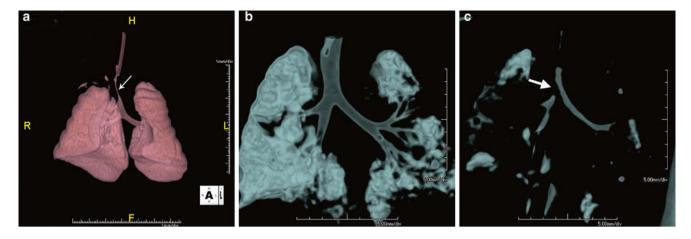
(a) shows CT 3D colorful reconstruction of an infant with longsegment tracheal stenosis previously unrecognized on conventional radiologic modalities. Volume renderings of the airways in a different infant in both inspiratory (b) and expiratory (c) phases demonstrate
